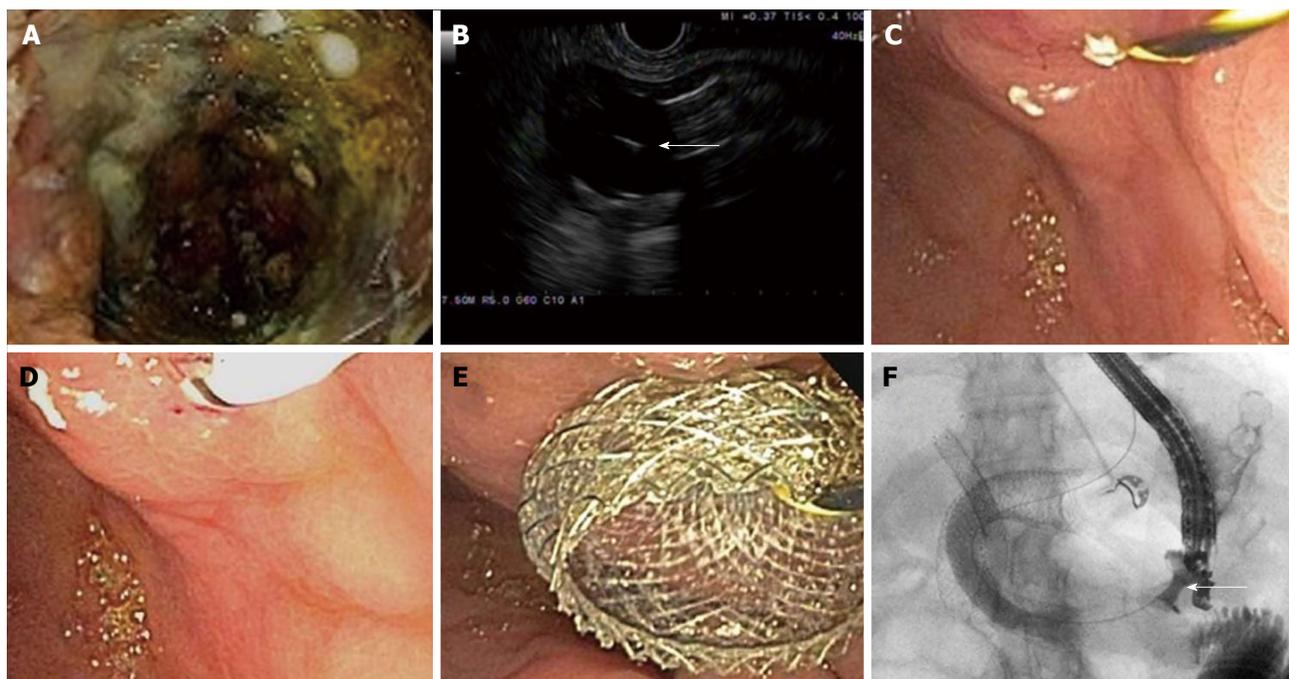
A 66 years old female with metastatic cholangiocarcinoma and gastric outlet obstruction undergoing endoscopic ultrasound-guided gastrojejunostomy. A: Tumor ingrowth into two previously placed duodenal stents; B: Endoscopic ultrasound visualization of a 20 mm balloon inflated in the proximal jejunum followed by a 19-gauge needle puncture (arrow); C and D: Balloon dilation of the gastrojejunal fistula over a 0.035 inch guidewire; E and F: Endoscopic (E) and fluoroscopic (F) demonstration of contrast flow across 10 mm × 15 mm lumen-apposing metal stent (arrow) into the jejunum.
